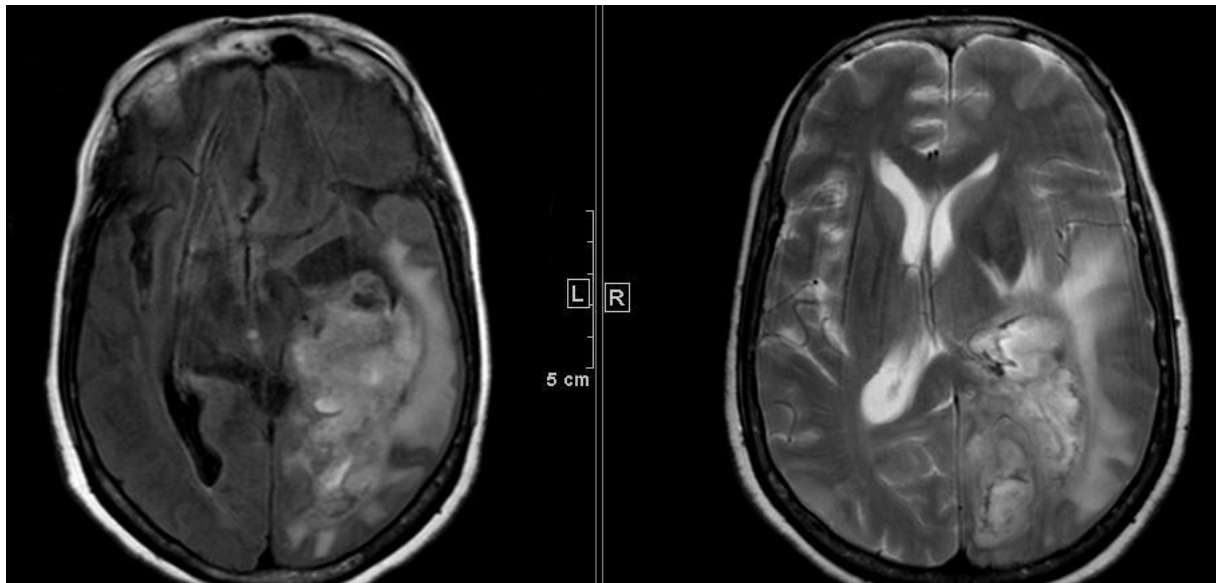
Magnetic resonance imaging in a patient with a left parietal glioma that has indistinct borders on the T2w and T2 flair axial images (a and b)There is marked perilesional edema.
